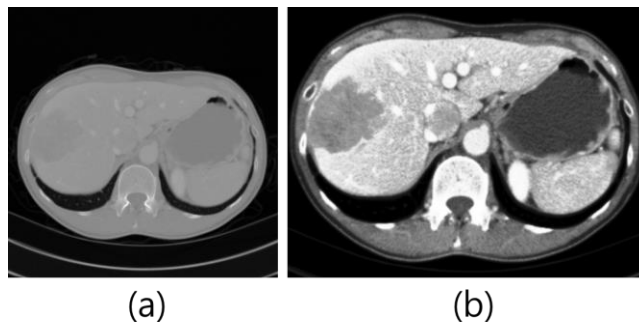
Image preprocessing: (a) abdominal CT image before preprocessing, (b) image preprocessing result.
